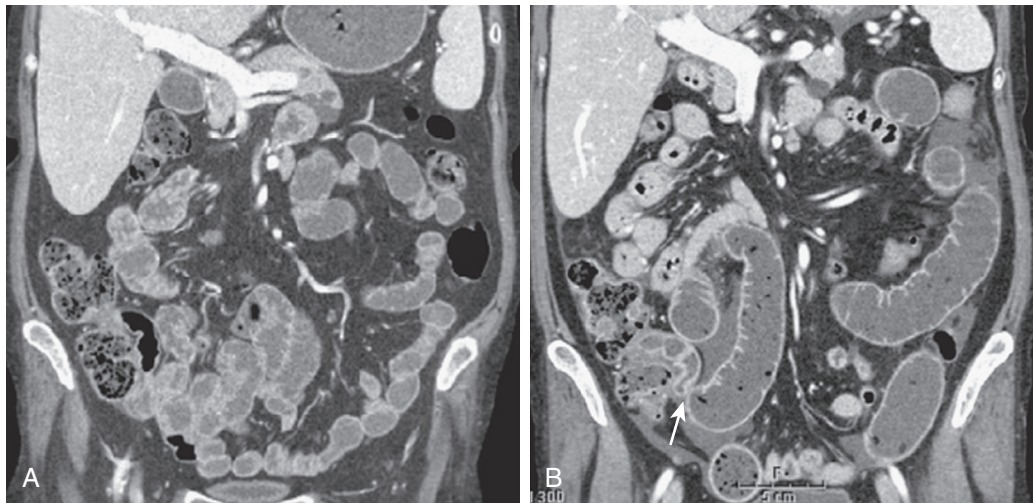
Demonstration of transition point and prestenotic dilation. A. Coronal image of CT abdomen and pelvis with orally ingested neutral contrast shows filling loops of the SB, including distal loops, but no evidence of mechanical obstruction seen in patient with tuberculous stricture (same patient as in Fig. 39-1). B. Stricture now apparent (arrow) with prestenotic dilation during enteral volume challenge. Note the so-called dirty feces sign from inspissated debris. (From Gollub MJ, Maglinte DD: *CT enterography and CT enteroclysis*. In Shirkhoda A [ed]: *Variants and Pitfalls in Body Imaging*, 2nd ed. Philadelphia, Lippincott Williams & Wilkins, 2011, pp 328–362.)
